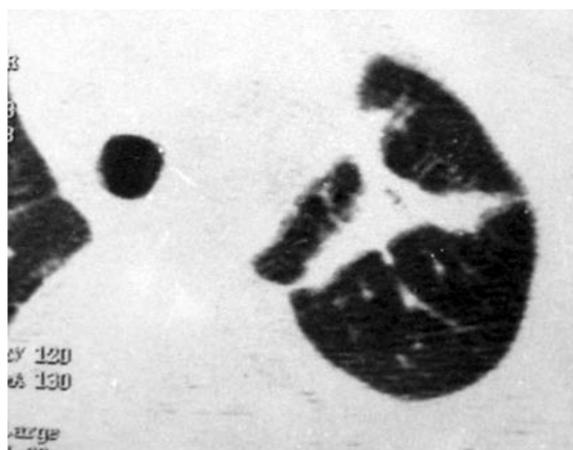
HRCT scan of a 16 years old female patient with SLE of 2 years duration. Bilateral diffuse hazy increased density (ground-glass appearance) is noticed.
